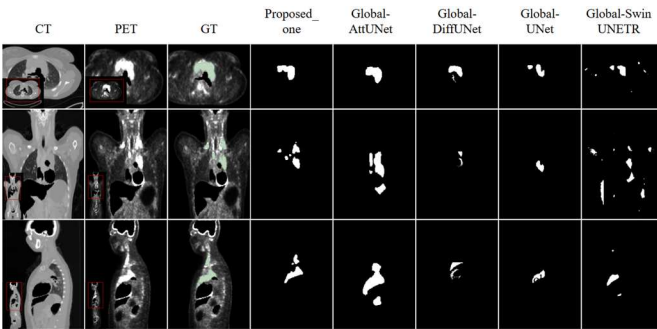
Qualitative comparison of different methods in the global segmentation stage for PET/CT lymphoma segmentation task
